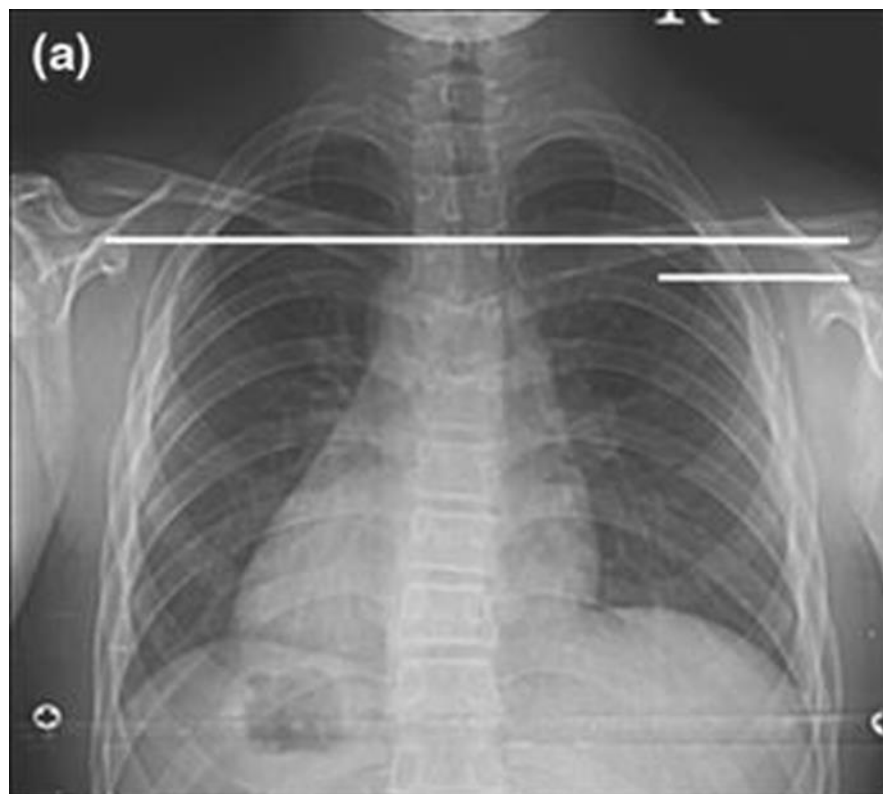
Radiographic measurement of shoulder asymmetry.
